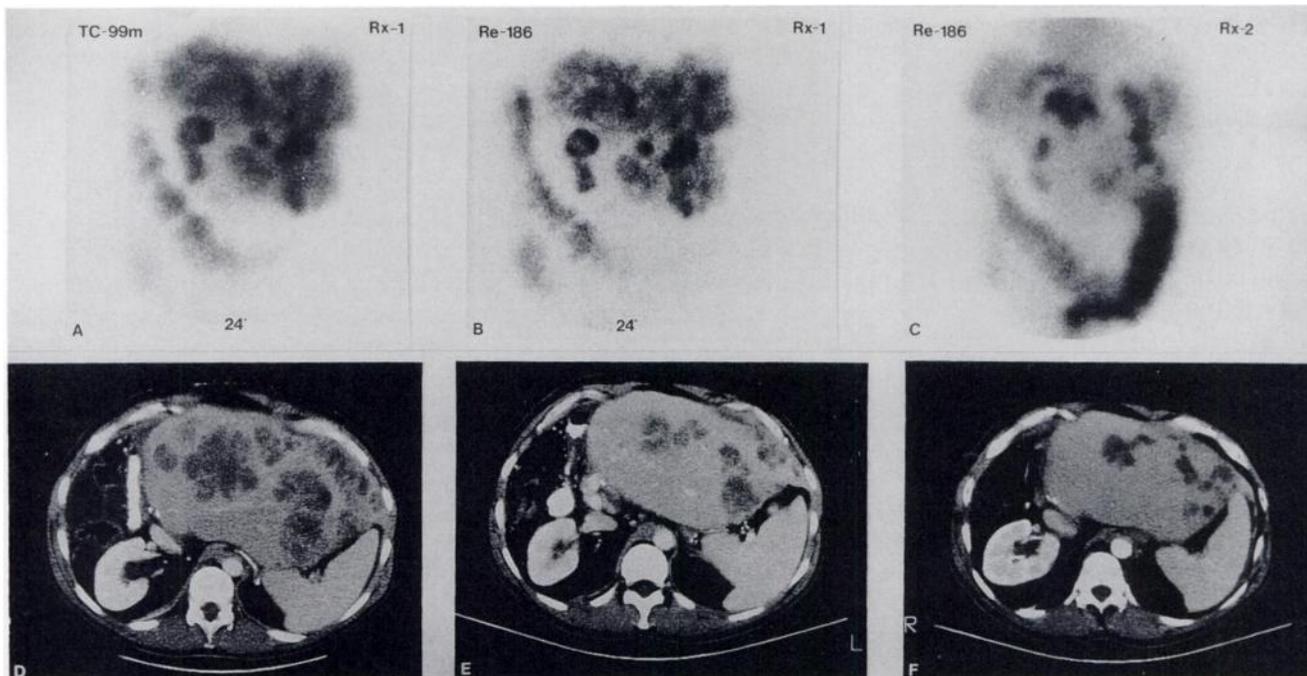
Patient 30.04 who responded twice to $^{186}\text{Re-NR-CO-02 F(ab')}_2$. Anterior abdominal gamma camera images showing radionuclide accumulation in multiple hepatic metastases: (A) $^{99\text{m}}\text{Tc-NR-CO-02}$ images prior to therapy; (B) at 20 hr following 142 mCi $^{186}\text{Re-NR-CO-02}$; and (C) at 72 hr following 146 mCi $^{186}\text{Re-NR-CO-02}$ (second dose). CT scans of a comparable level through the liver: (D) prior to $^{186}\text{Re-NR-CO-02}$; (E) 4 wk following first treatment; and (F) 4 wk following second treatment.
